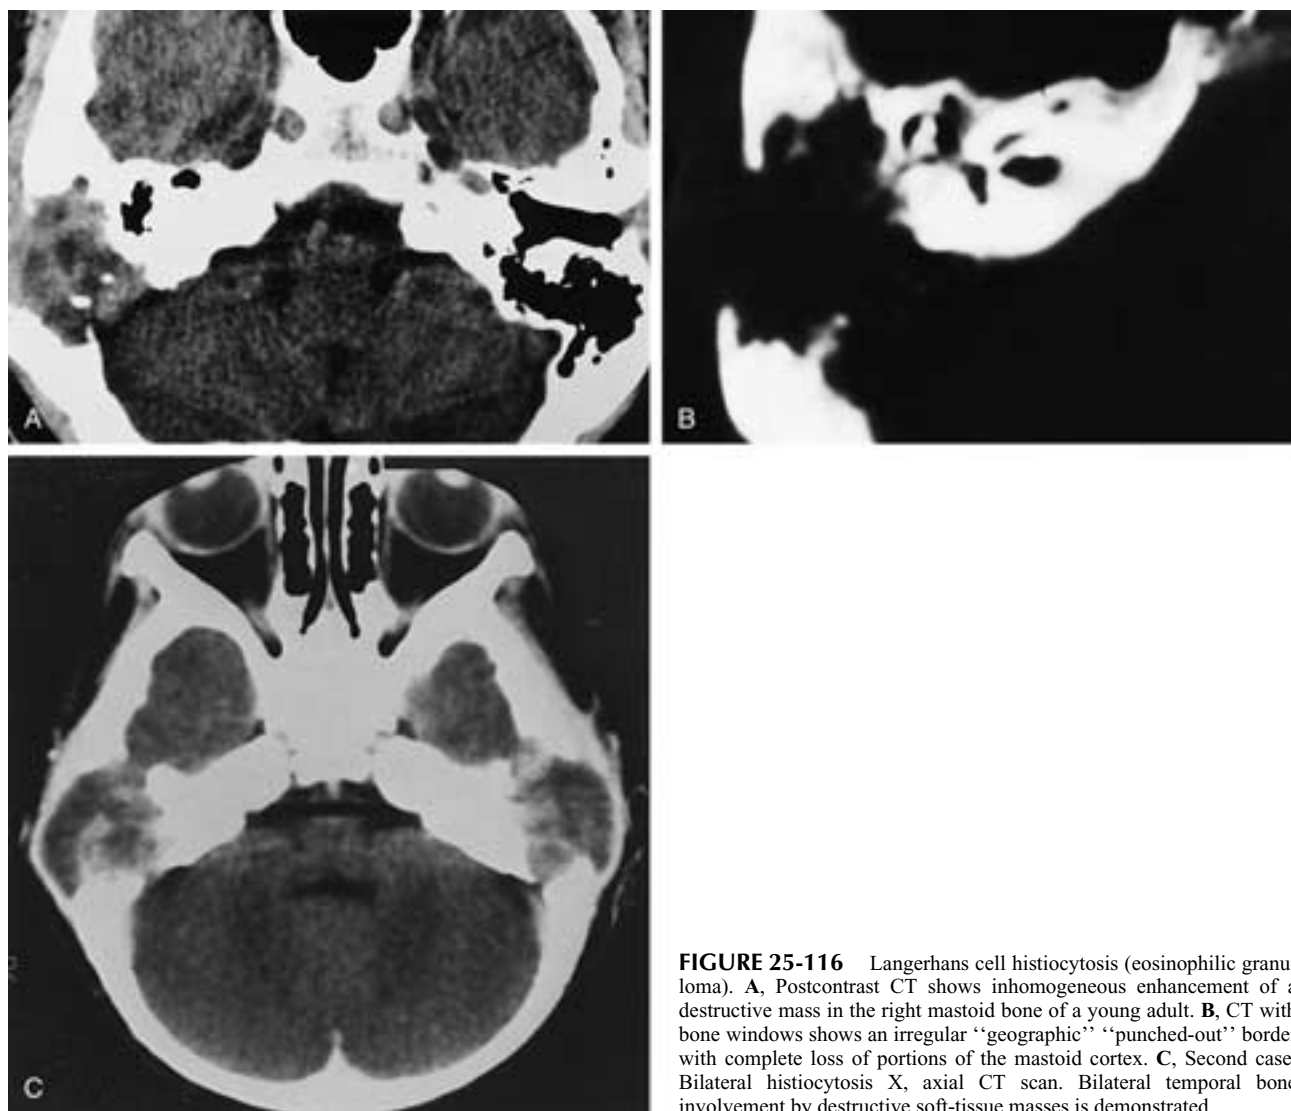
Langerhans cell histiocytosis (eosinophilic granuloma). A, Postcontrast CT shows inhomogeneous enhancement of a destructive mass in the right mastoid bone of a young adult. B, CT with bone windows shows an irregular “geographic” “punched-out” border with complete loss of portions of the mastoid cortex. C, Second case. Bilateral histiocytosis X, axial CT scan. Bilateral temporal bone involvement by destructive soft-tissue masses is demonstrated.
